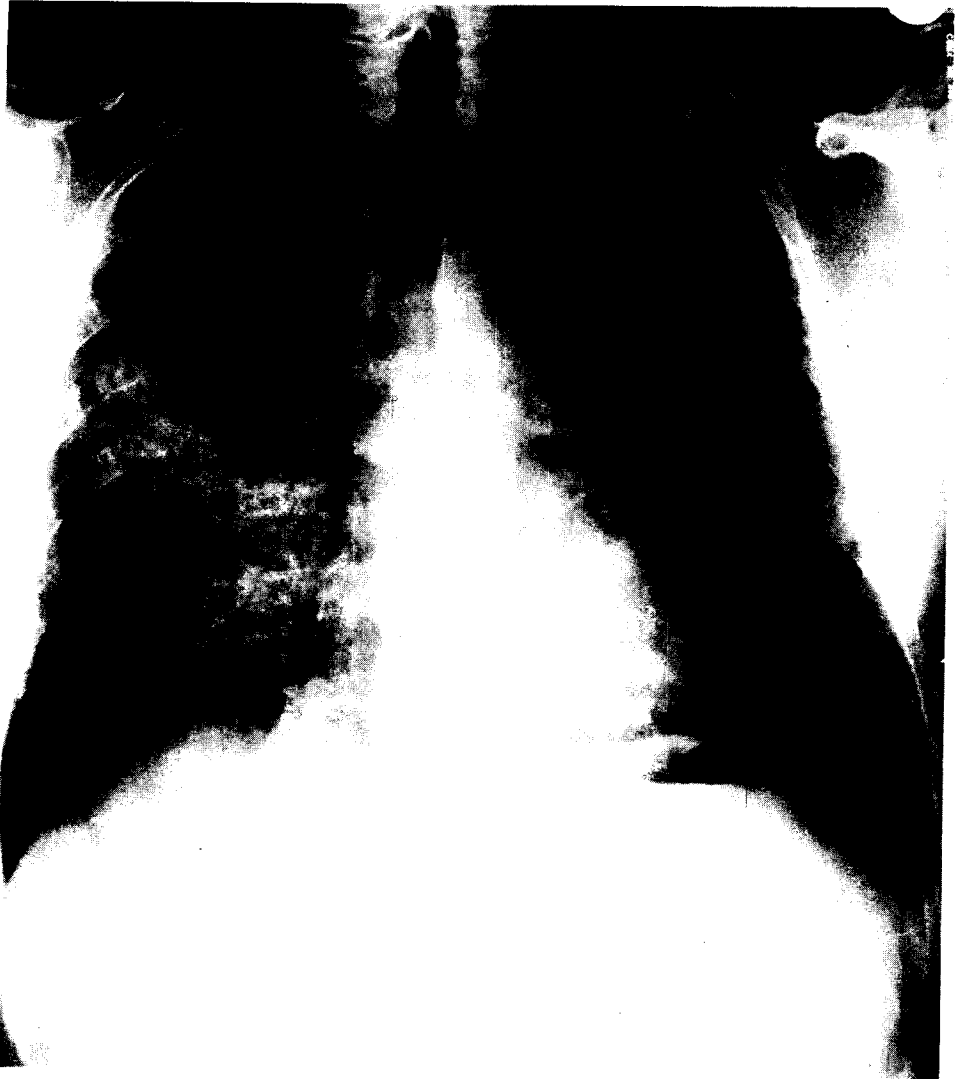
Chest x-ray of patient A before lung lavage.
